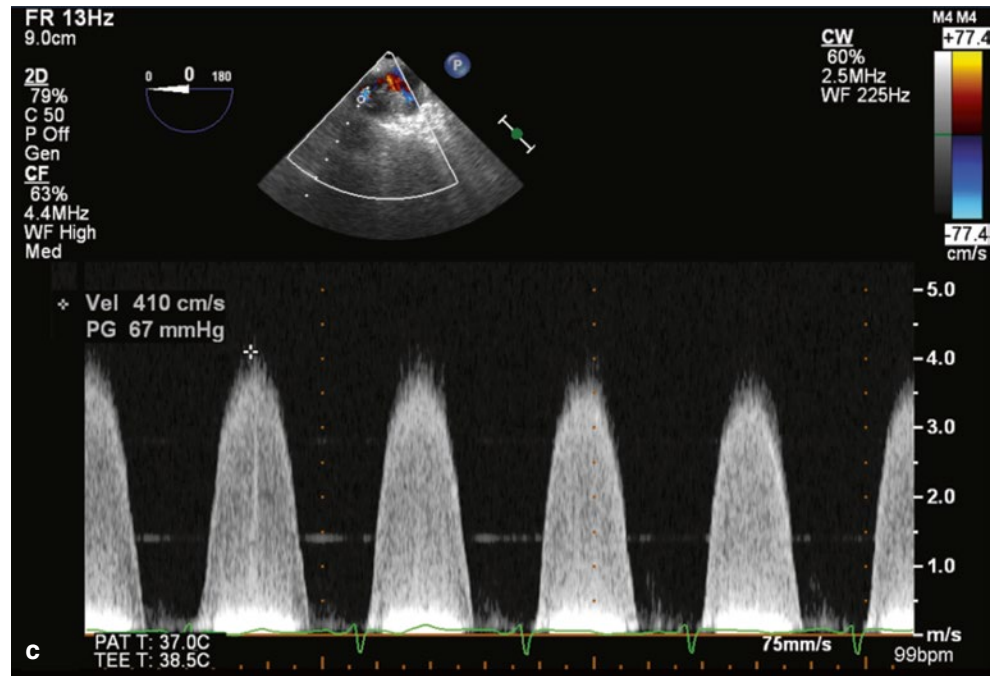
Spectral display of aliasing by pulsed wave Doppler echocardiography in a patient with pulmonary conduit stenosis. The display “wraps around” so that the Doppler tracing is cut off at the top and appears to arise from the bottom of the screen, protruding through the baseline and up into the same wave (a). Even moving the baseline down to allocate the entire frequency range to the signal still results in an aliased signal (b). This indicates that the Doppler frequency of the signal is higher than the Nyquist limit for this particular transducer (operating at 2.9 MHz). When continuous wave Doppler evaluation is performed, a high velocity of over 4 m/s is measured, adequately resolved by this modality (c)
